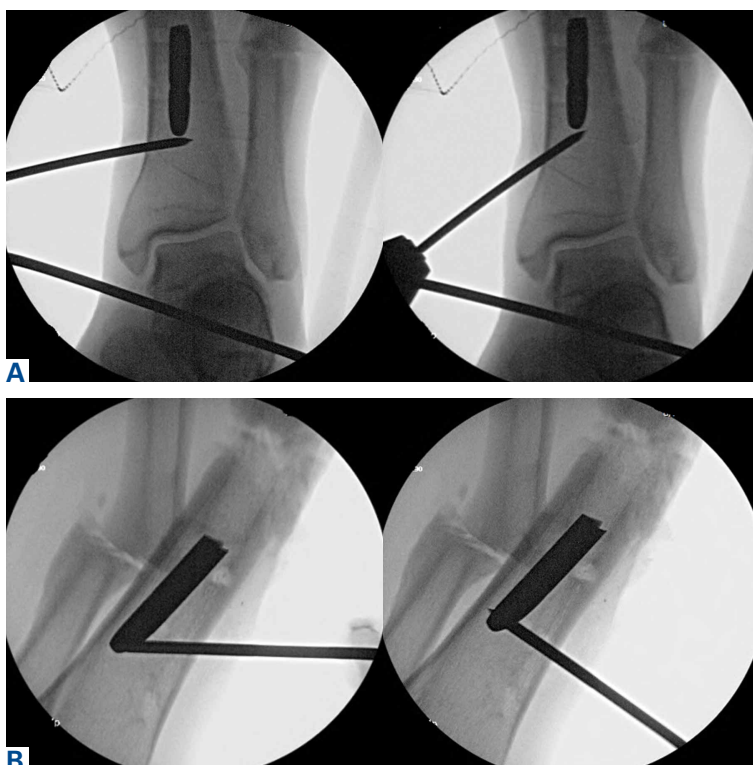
(A) Anteroposterior and (B) lateral radiographs show levering technique with medial cortex used as fulcrum. Nail being pushed by smooth pin can be visualized moving proximally.
